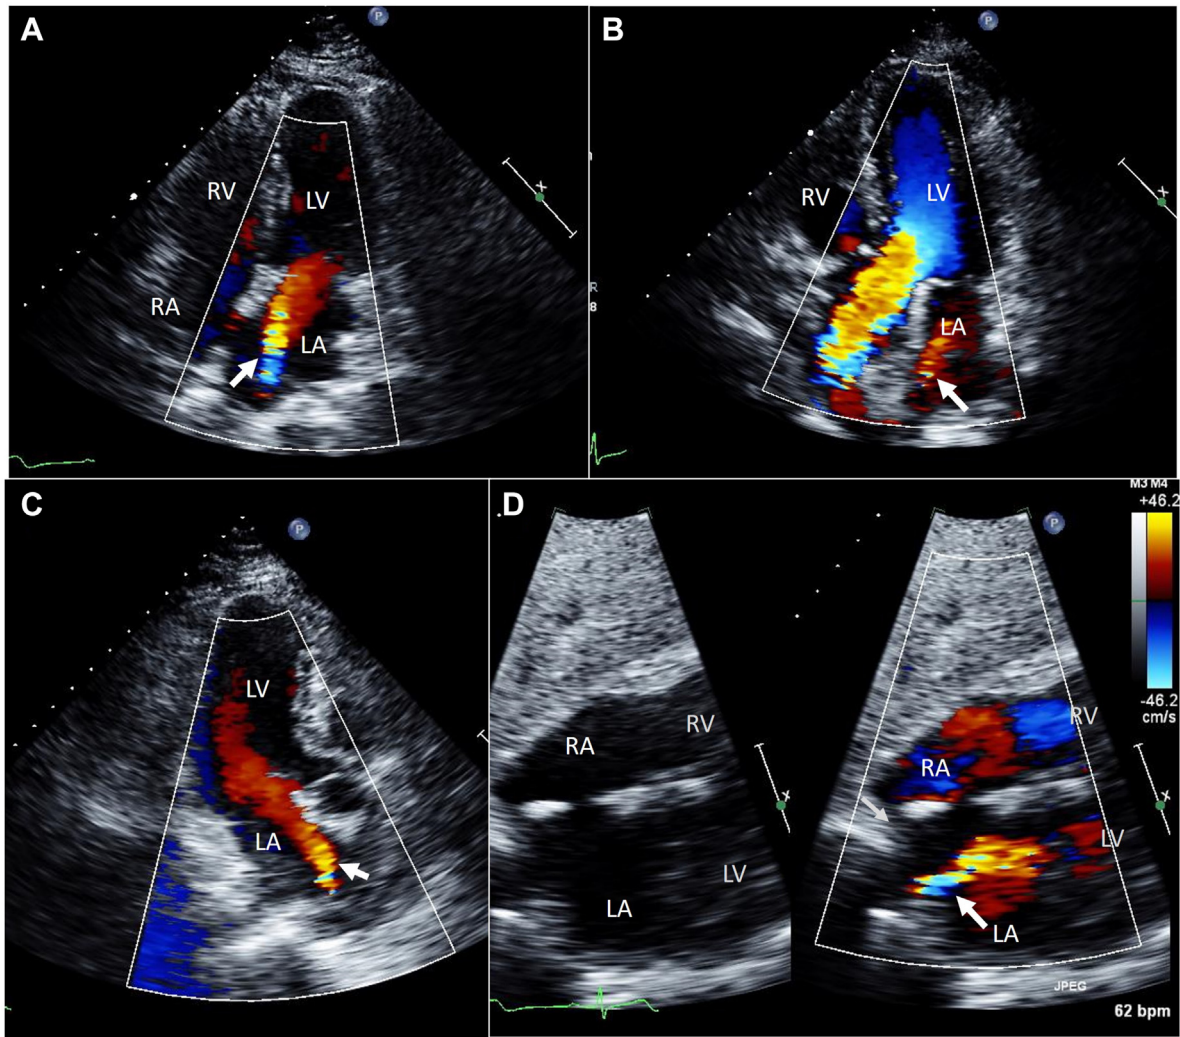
Two-dimensional TTE, apical 4-chamber (A), 5-chamber (B), and long-axis (C) views with color-flow Doppler, and subcostal dual-display view (D) without (left) and with (right) color-flow Doppler, demonstrates color-flow aliasing (arrows) from a right PV. LV, Left ventricle; RA, right atrium; RV, right ventricle.
